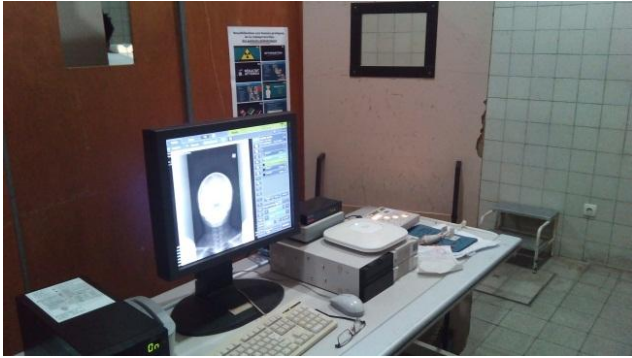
(a and b): Imaging Service Digital Radiography System with Direct Acquisition (DR) System
